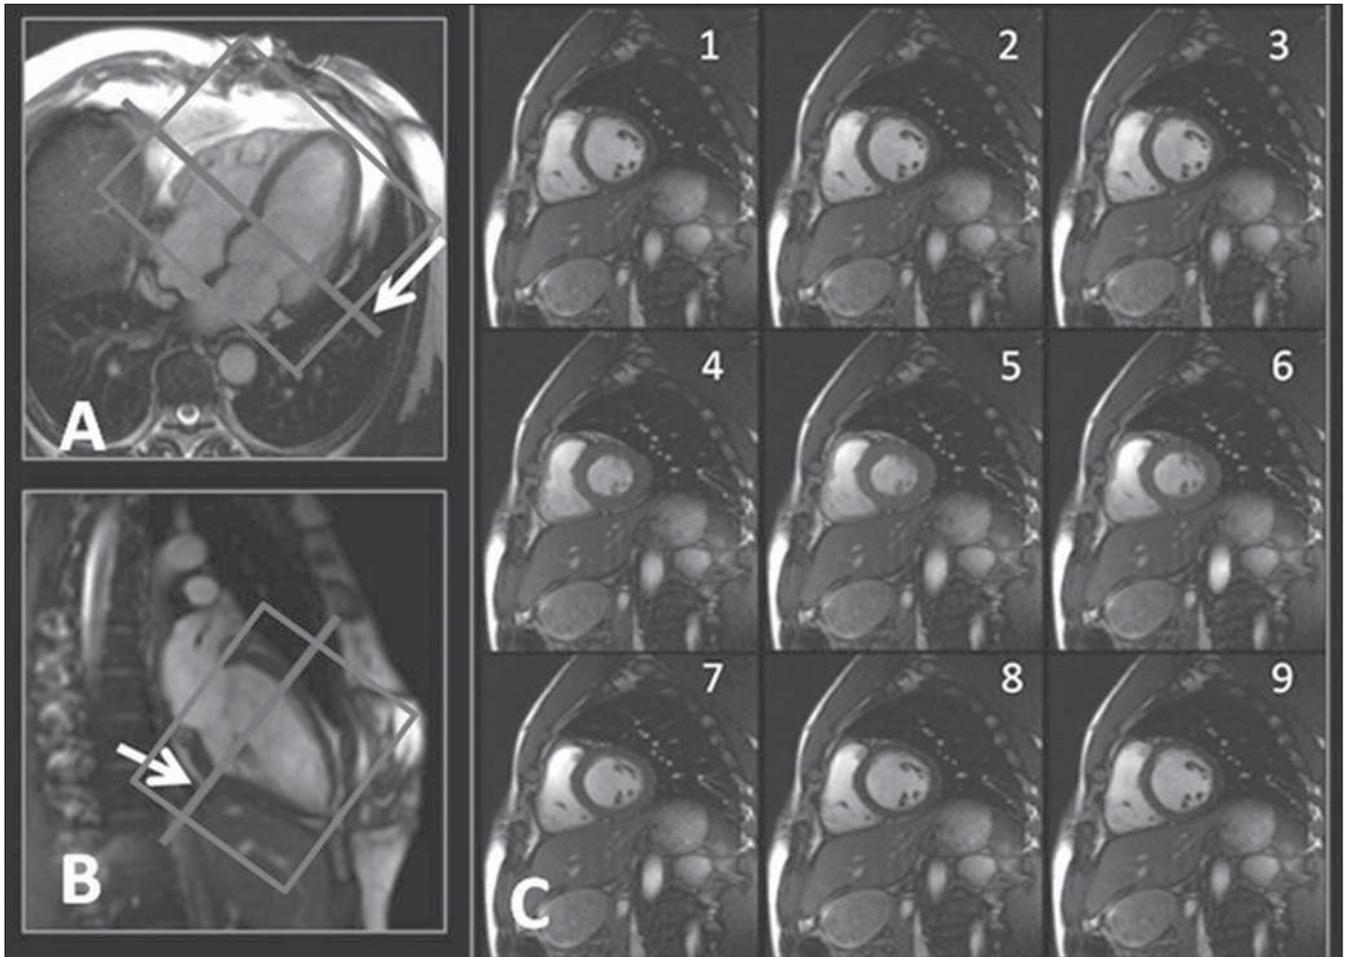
A,B: Scheduling of sections on left ventricle short axis orthogonal to the interventricular septum. C: Some of the images included in the series of standard cine MRI sequences in the slice positioning indicated by the arrows on A and B.
